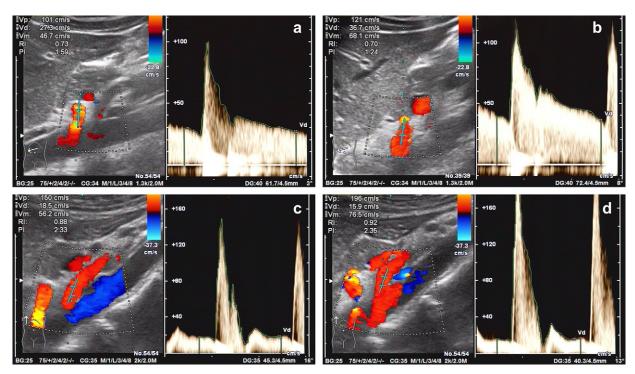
Color and duplex Doppler images of the celiac trunk during inspiration (a) and expiration (b) as well as the superior mesenteric artery during in- (c) and expiration (d). Doppler angles are shown in the lower right corner of the images.
